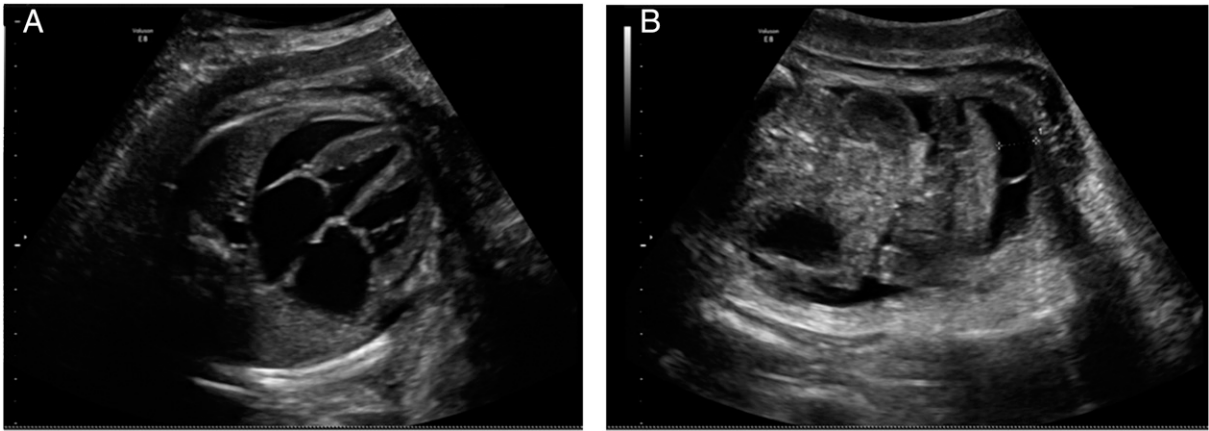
Pericardial effusion (A) and ascites (B) on fetal ultrasonography.
